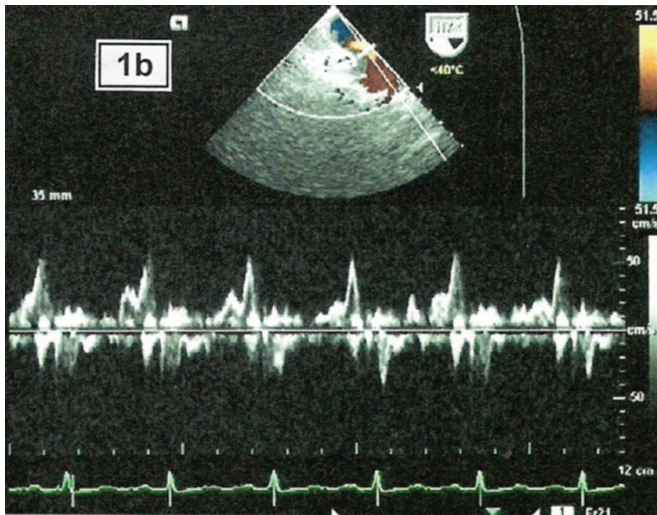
Transesophageal echocardiographic view showing left sided pulmonary veins.
